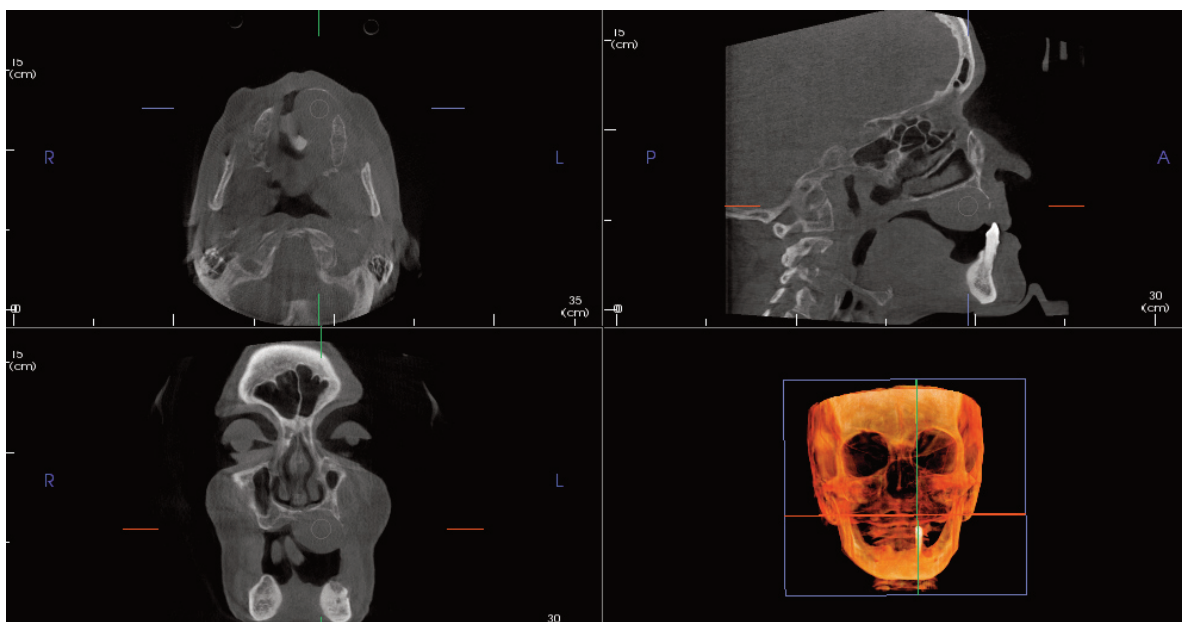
CBCT compilation of lesion on initial exam appointment
